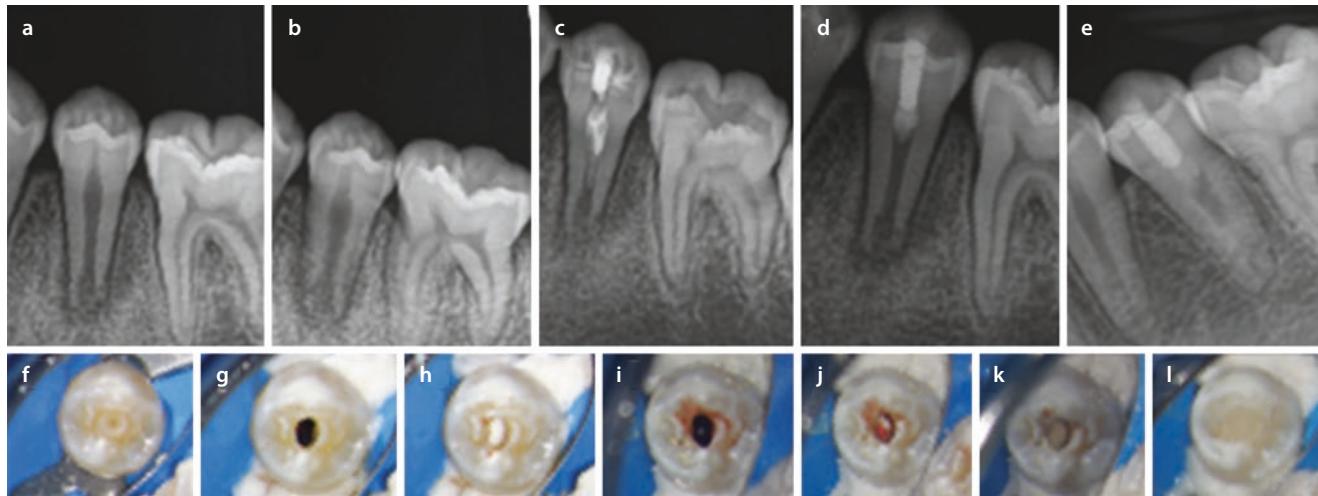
a, b Pre-operative radiographs of immature tooth #20 f with necrotic pulp and chronic apical abscess. Pulpal repair was recommended and completed in two visits. First visit: accessed, chemically derided g, and placement of CaOH c, h for 4 weeks. Second visit:
